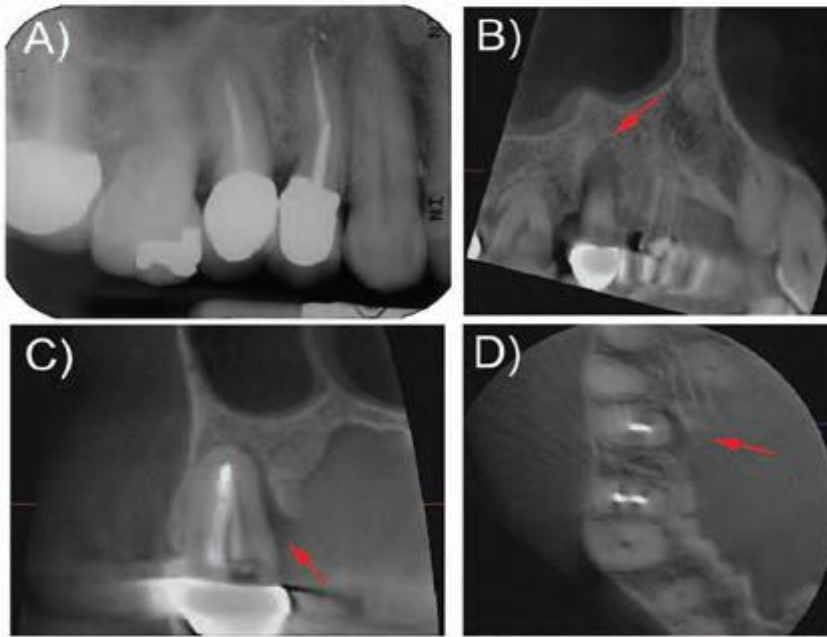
Periapical (a), sagittal (b), cross-sectional (c), and axial (d) CBCT sections of 14 tooth. Red arrow on CBCT images points to periodontal defect. CBCT images in this and the remaining figs were generated by the limited FOV 3-D Accuitomo CBCT scanner.
